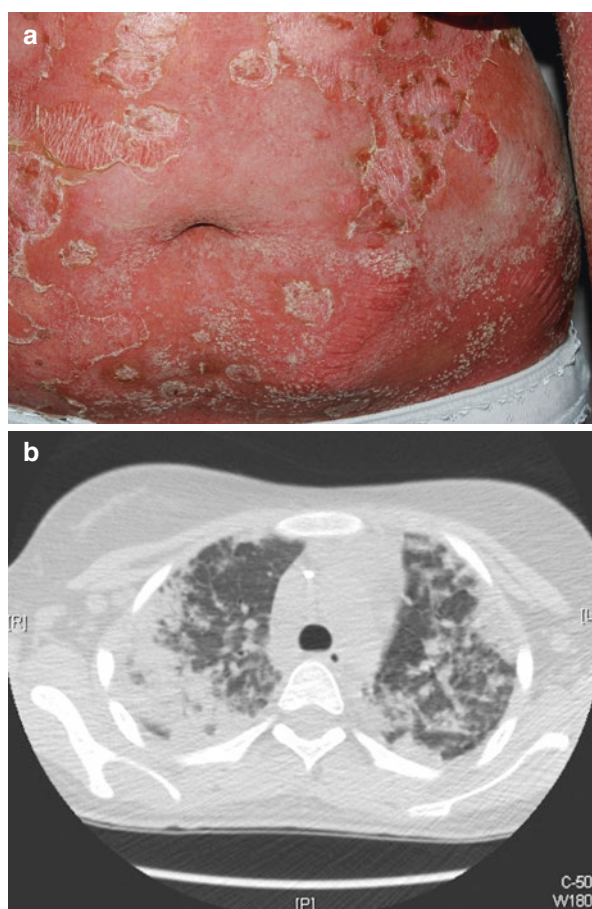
Generalized pustular psoriasis associated with aseptic pneumonitis in a 14-year-old girl. (a) Pustular psoriasis of the abdomen. (b and c) Thoracic CT scan shows bilateral interstitial infiltrate and alveolar findings. Note the predominance of infiltrate in upper lobes and bilateral pleurisy
